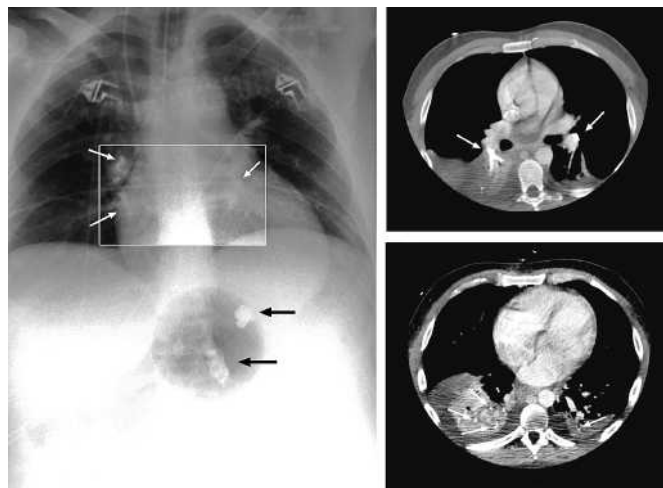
Left: A chest radiograph showing multiple pulmonary emboli (white arrows) and two large fragments of Cyanoacrylate in the upper abdomen (black arrows). Top right: Postoperative computed tomogram, showing multiple cyanoacrylate pulmonary emboli on both sides (arrows), with an increased signal intensity in the segmental and subsegmental pulmonary arteries. Bottom right: Computed tomograph approximately 2 weeks after the onset of the pulmonary emboli, showing pulmonary infarction, formation of bullae, extensive consolidation, pleural effusions, and residual enbucrilate (arrows).
